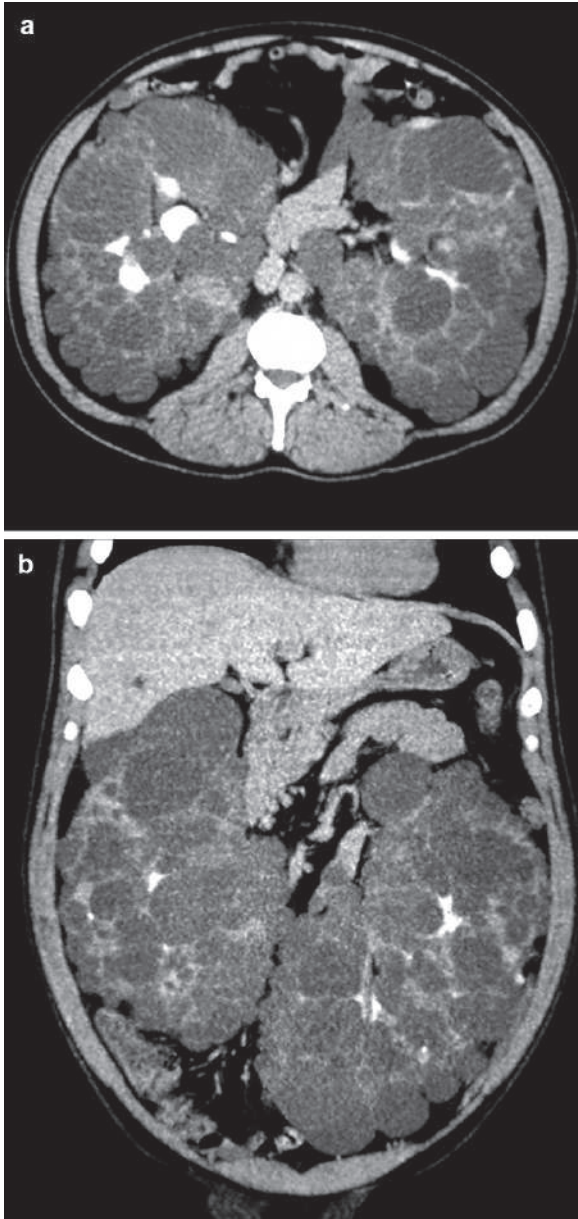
Axial (a) and coronal (b) CT urography images in a child with ARPKD show massively enlarged kidneys with numerous small cysts bilaterally
